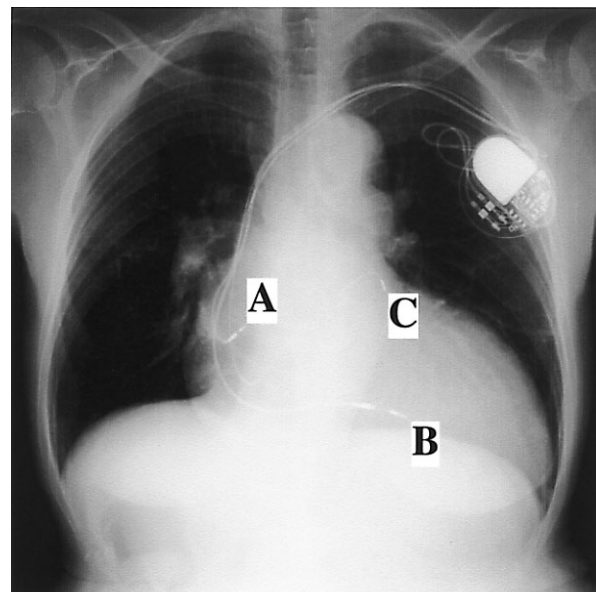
Chest roentgenogram obtained immediately after the BVP therapy. A, right atrial lead; B, right ventricular lead; C, left ventricular lead that had been placed into a distal cardiac vein by way of the coronary sinus.
